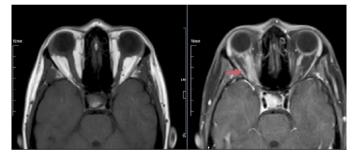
High signal intensity at the right opticnerve. Axial T1weighted MRI scans of the orbits MRI: Magnetic resonance imaging
